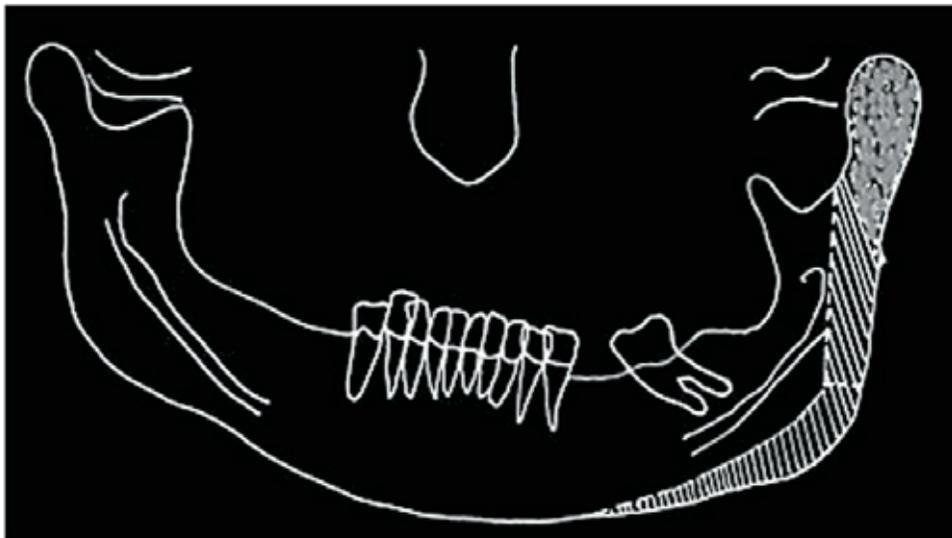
General plan of the osteotomies using a tracing on the panoramic radiograph.
